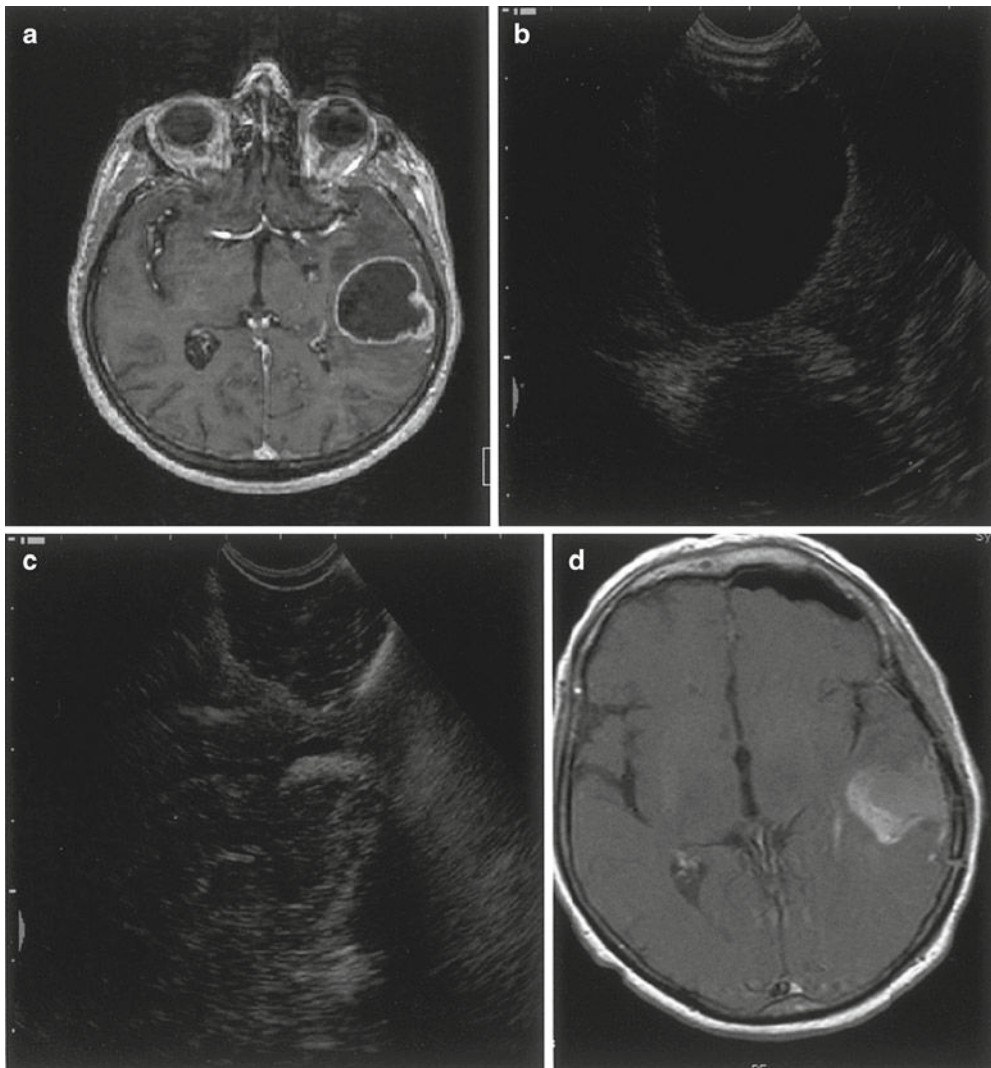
Pictures demonstrate the radiographic complete resection of a cystic left temporal glioblastoma multiforme. Preoperative MRI (a), intra-operative ultrasound (b) with a sonographic relatively sharp defined cystic wall, sonographic resection control (c) and postoperative MRI with contrast medium without tumor suspected masses (d)
